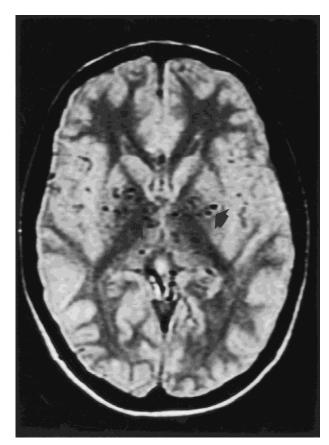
T1-weighted axial magnetic resonance imaging (MRI) at the level of the basal ganglia showing multiple area of vascular ectasia (arrows).
